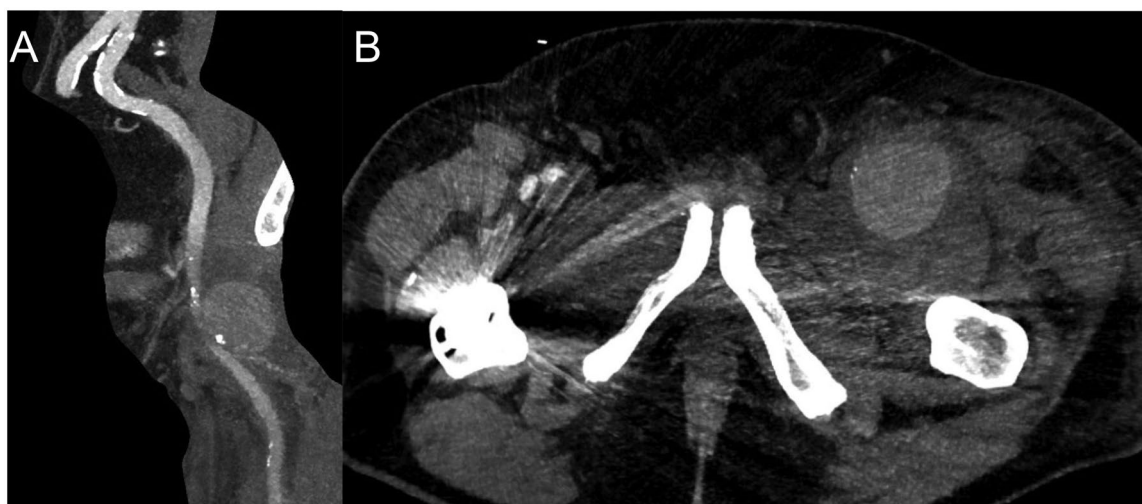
(A) Curved multiplanar reconstruction of the left ilio-femoral axis and (B) transverse plane of angio-CT showing a large mycotic pseudoaneurysms developed at the left ilio-femoral junction.
